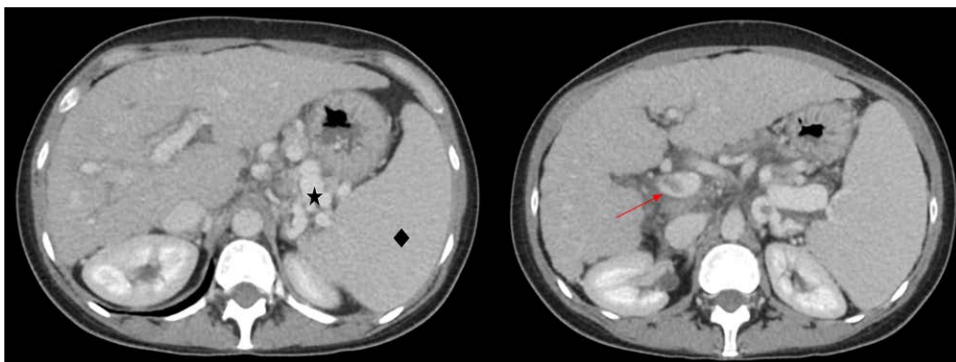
Preoperative CT scan. The first image shows splenomegaly marked with a black diamond and prominent collateral esophageal vessels marked with a star. The second image shows portal vein thrombosis marked with a red arrow. CT, computed tomography.
